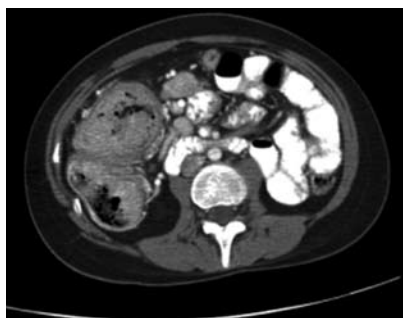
Abdominal computed tomography showing a mass at the splenic flexure.
